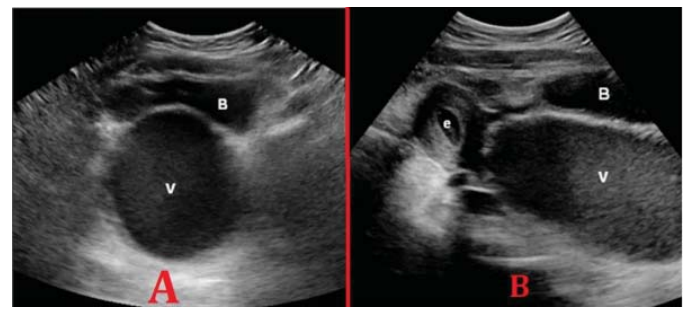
Ultrasound aspect of hematocolpos.
